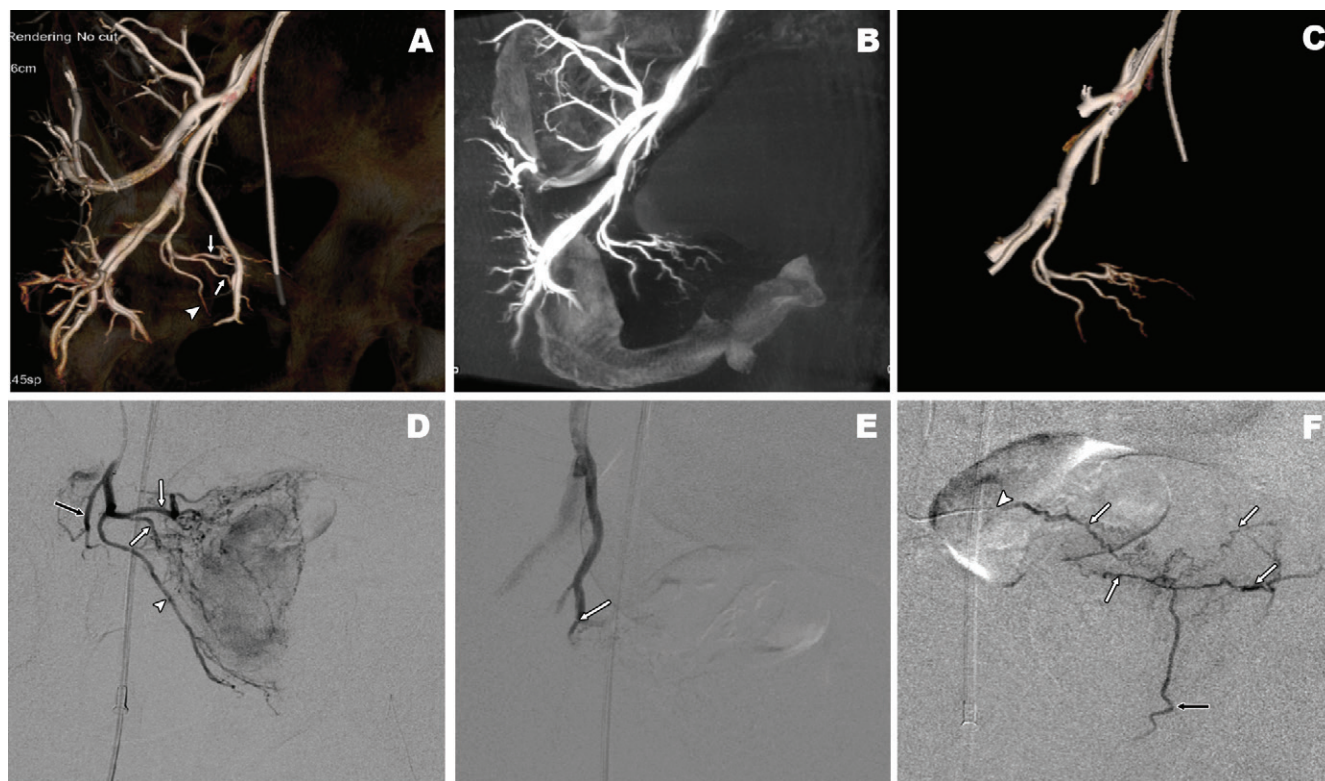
A, Three-dimensional rotational angiography reconstruction using cone-beam CT software shows right prostatic posterolateral (arrowhead) and anteromedial branches (arrows), as well as other right-sided pelvic arteries. B, Reconstruction, including soft tissues, confirms right-lobe prostatic vascular anatomy. C, Arterial segmentation reconstruction shows best oblique angulation to be used as road-map guide, avoiding use of additional digital subtraction arteriogram (DSA). D, Selective ipsilateral oblique DSA shows right posterolateral (arrowhead) and anteromedial (white arrows) prostatic branches, right seminal vesical artery (black arrow), and right-lobe intraprostatic branches. E, DSA after embolization with tip of microcatheter at main trunk of prostatic artery (arrow) shows occlusion of distal intraprostatic branches, and reflux to origin of right prostatic artery. F, After distal navigation of microcatheter (arrowhead) for Proximal Embolization First, Then Embolize Distal technique, DSA shows intraprostatic branches still patent (white arrows) and opened collateral shunt (black arrow).
